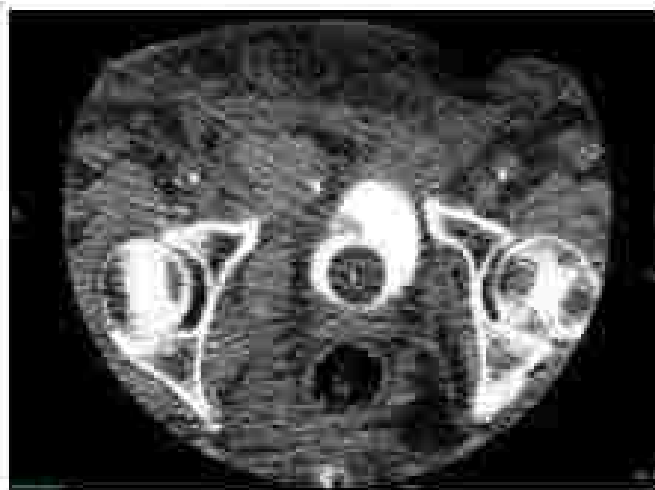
Computed tomography cystogram demonstrating bony spicule in bladder lumen in a patient with intraperitoneal bladder injury.
